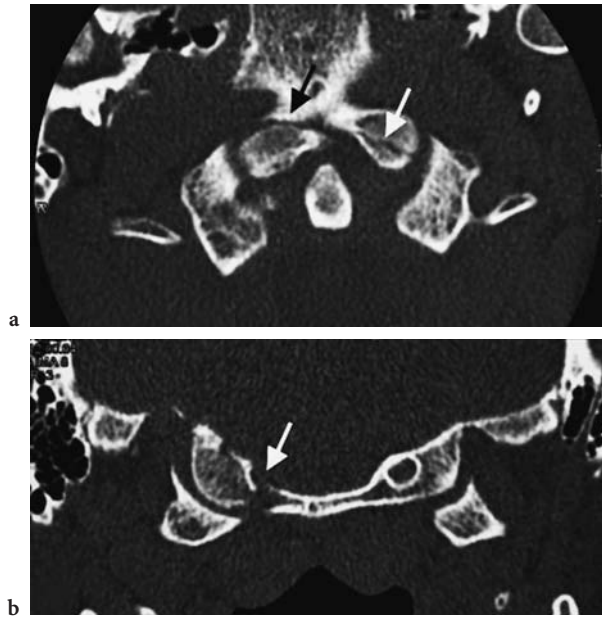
Condylar fracture: type II, extensive type. a Axial CT image. b Coronal CT reformation. Bilateral condylar fractures (white arrows) extending into the basion (black arrow)
